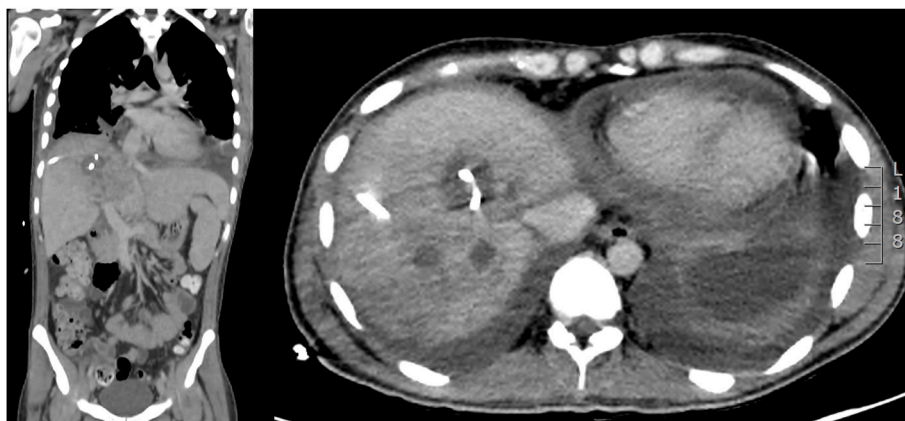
CT scan showing two drains in the superior and in the inferior part of the liver abscesses. The scan was performed right after the ultrasound-guided drainage.
